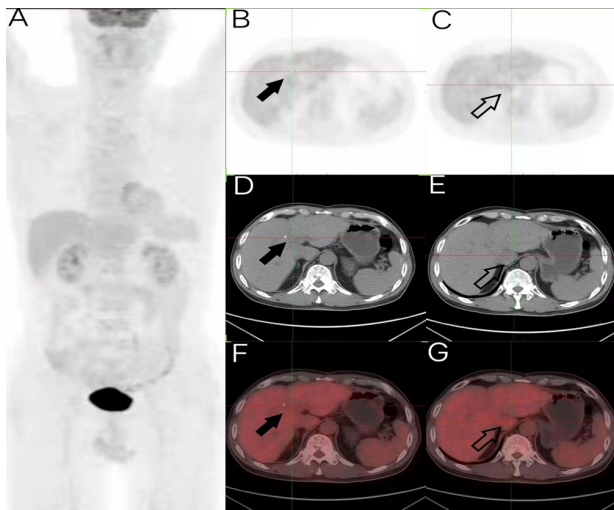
¹⁸F-FDG PET/CT was performed to evaluate primary lesion. (A) The maximal intensity projection image and PET axial views (B, C) and views of CT (D, E) and views of fused PET/CT (F, G) showed some small round hypodense or isodense nodules (B, D, F arrowhead; C, E, G hollow arrow) in the liver without increased uptake.
